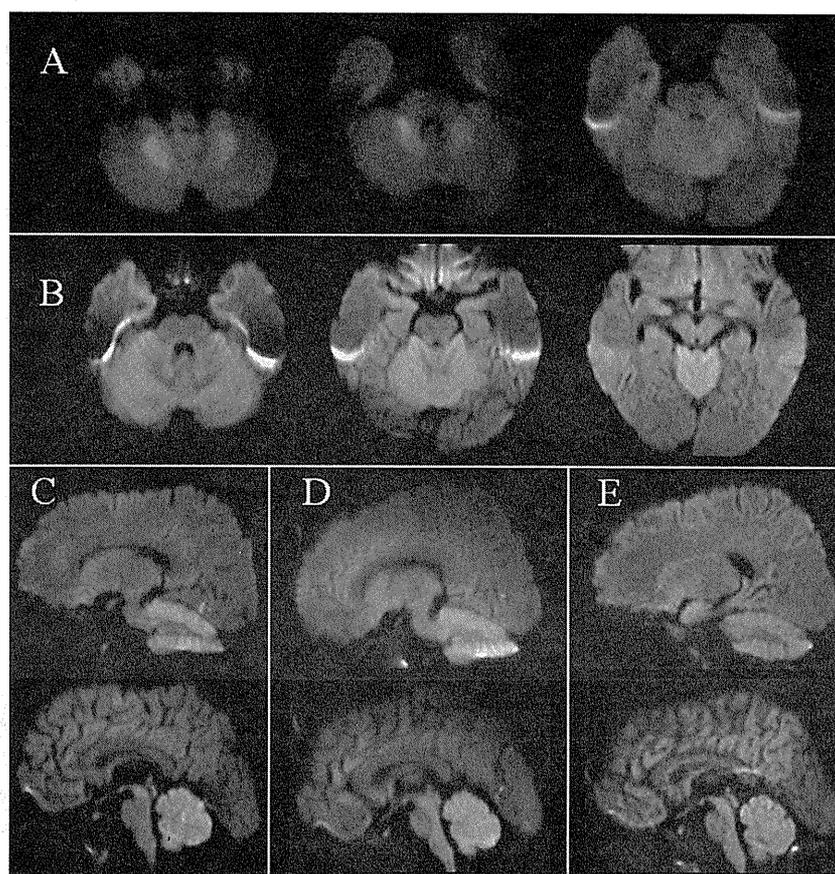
MRI findings in case 2. (A) Axial DWI on day 1 showed marked hyperintensity in the bilateral dentate nucleus without cerebral lesions. (B) Axial DWI on day 3 showed marked hyperintensity in the bilateral dentate nucleus followed by hyperintensity in the vermis and cerebellar hemisphere. (C) Sagittal DWI on day 9 showed marked hyperintensity in cerebellar hemisphere. (D) Sagittal DWI on day 15 showed marked hyperintensity in cerebellar hemisphere, especially in lower part of cerebellar hemisphere. (E) Sagittal DWI on day 23 showed decreased hyperintensity in cerebellar hemisphere.
